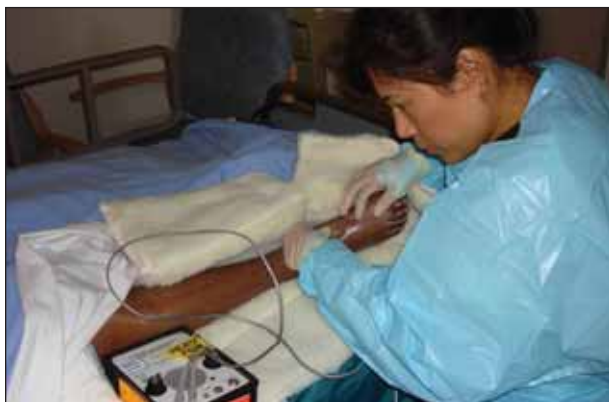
Doppler evaluation and measurement of ABIs should be part of the regular bedside assessment of perfusion in patients with chronic or acute limb ischemia.
